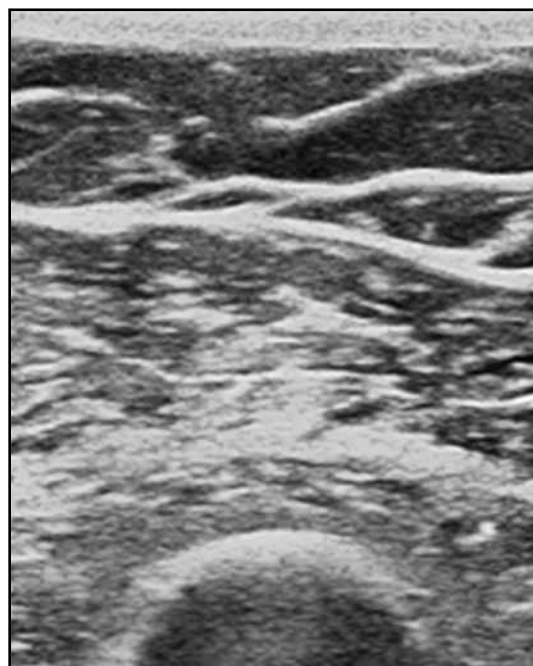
Ultrasound of biceps in a patient with amyotrophic lateral sclerosis showing severe neurogenic changes.
